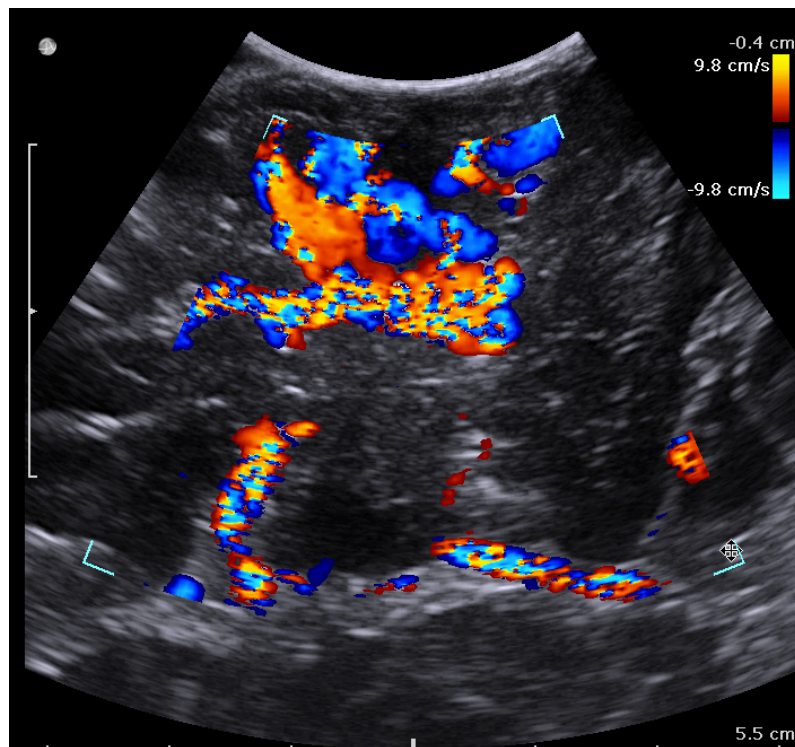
Colordoppler ultrasound acquisition
